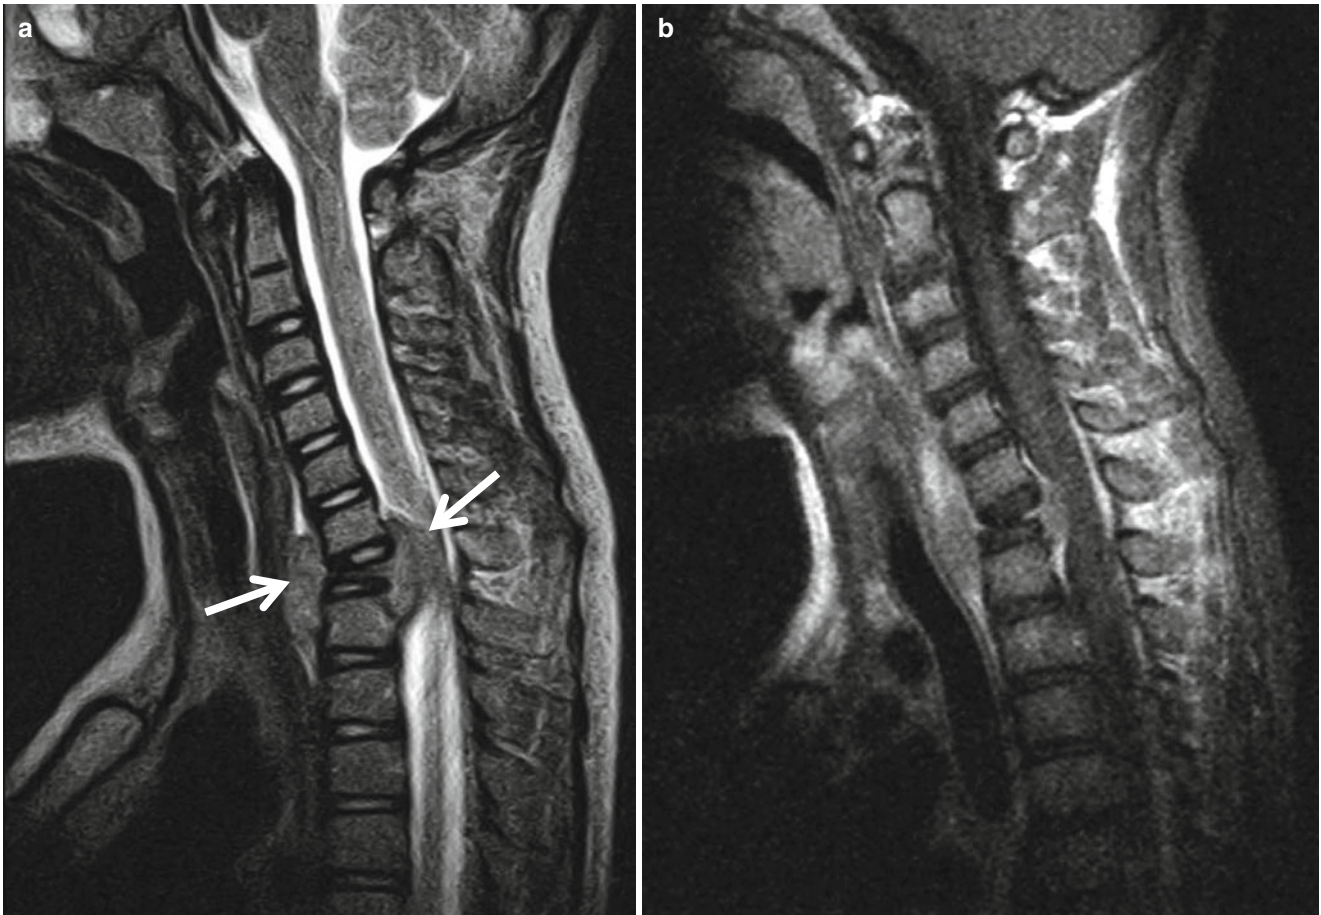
Langerhans cell histiocytosis forming epidural mass. (a) T2-weighted sagittal image shows flat C7 vertebra associated with epidural and prevertebral masses (*arrows*) of iso-signal intensity. (b) The soft tissue masses are enhanced on a postcontrast image
